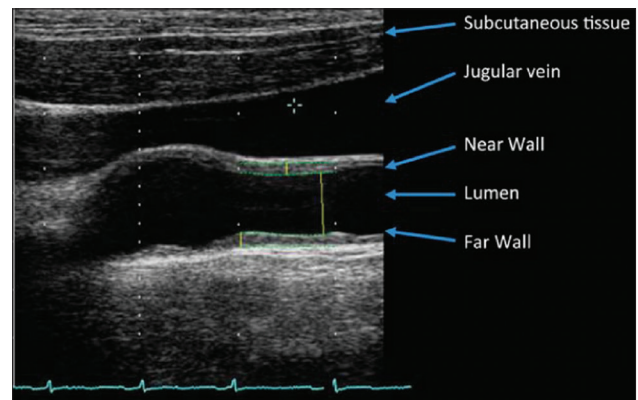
A typical B-mode ultrasound image from the carotid artery.^[19]
